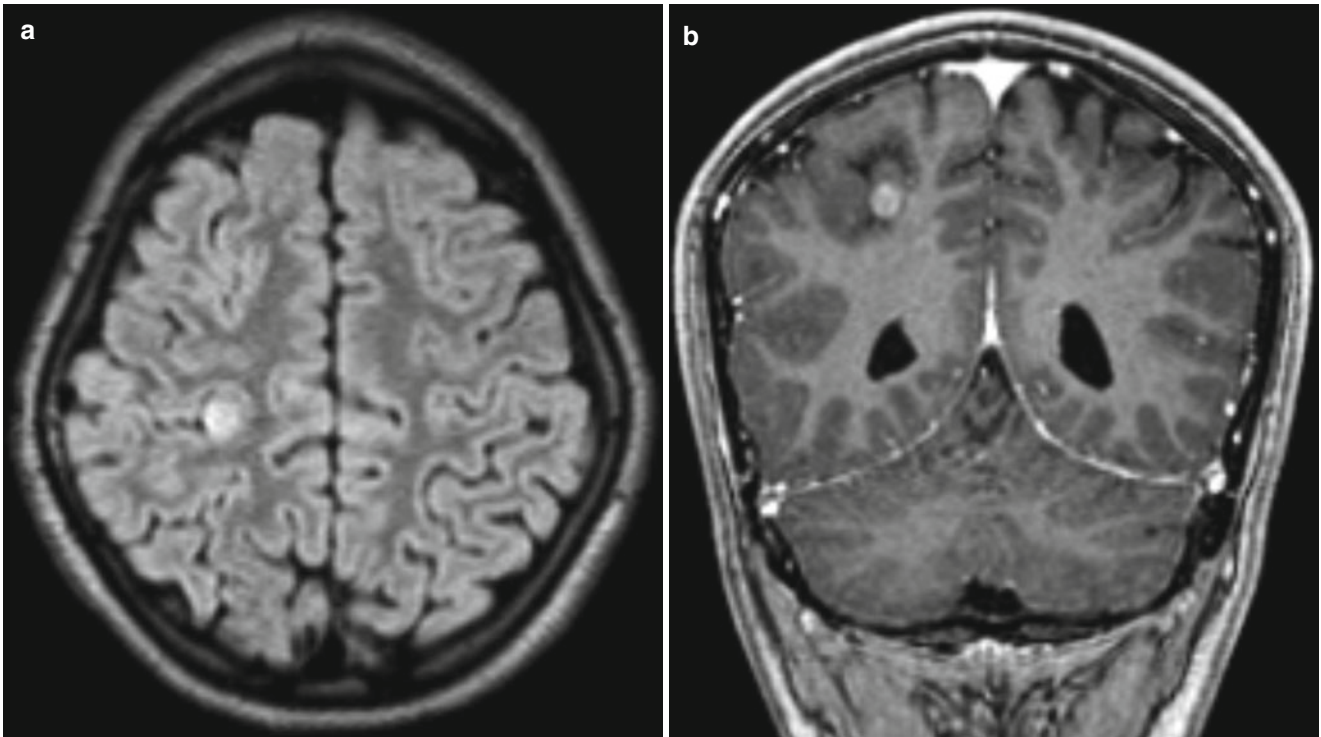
(a, b) Ganglioglioma close to the right postcentral sulcus. (a) axial T2/FLAIR with a small, cortical/subcortical, nodular high-signal area in the right parietal lobe close to the postcentral sulcus; (b) coronal T1 with gadolinium shows contrast enhancement in the nodulus
